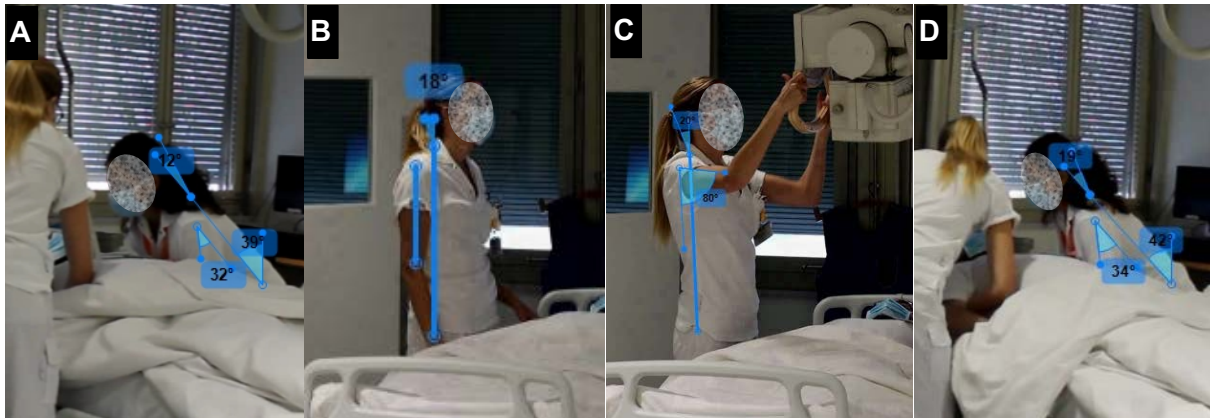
"Not acceptable" postures assumed by the medium (performer) and the shorter (helper) radiographers during bedside chest X-ray examination in scenario 4: a) the shorter radiographer during the preparation to position the detector under the patient's back; b) medium radiographer while waiting for the X-ray tube; c) medium radiographer during the X-ray tube positioning; d) shorter radiographer during the patient handling to remove the detector from under the patient's back.
